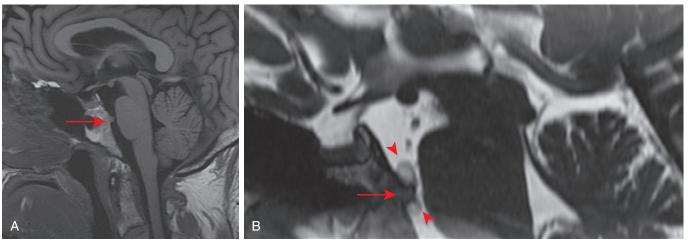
Ecchordosis physaliphora of the skull base and spine. A sagittal T1 spin echo (A) image shows a bony spicule arising from the posterior margin of the clivus (arrow), a key characteristic of this benign notochord remnant at the spheno-occipital synchondrosis. This lesion was only evident on a heavily T2-weighted sagittal FIESTA image (B), and indistinguishable from surrounding CSF on T2-weighted spin echo images. Note the characteristic T2 hyperintense, small, cystic lobulations (arrowheads) surrounding the bony spicule (arrow). The lesion did not enhance (not shown), another key imaging feature. Chordomas are associated with destructive bone components rather than hyperostotic bone components.
